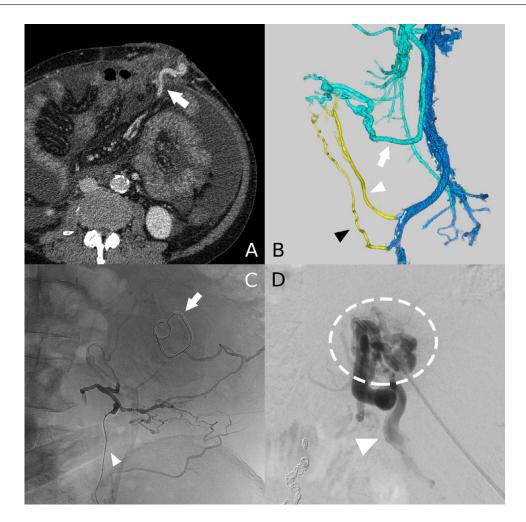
(A) Preoperative contrast-enhanced computed tomography (CECT). Dilated and tortuous inferior mesenteric vein (arrow) facing the stomal mucosa is observed. (B) Left lateral view (270° rotated) of 3D image based on preoperative CECT. Although left inferior epigastric vein (white arrowhead) and left superficial epigastric vein (black arrowhead) continue to the varices are confirmed, they are focally very narrow near the varices. The inferior mesenteric vein (white arrow) is seen as an afferent vein. (C) Retrograde transvenous venography using a 1.9-Fr microcatheter at the superficial epigastric vein. Retrograde transvenous venography is performed under temporary compression of the superficial epigastric vein instead of balloon occlusion (arrow head) and manual compression of other drainage vein (arrow). The varices are not found, but numerous other drainage veins are seen. (D) Digital subtraction angiography after ultrasound-guided direct puncture. Stomal varix (dotted circle) and the inferior mesenteric vein (arrowhead) as an afferent vein are found.
